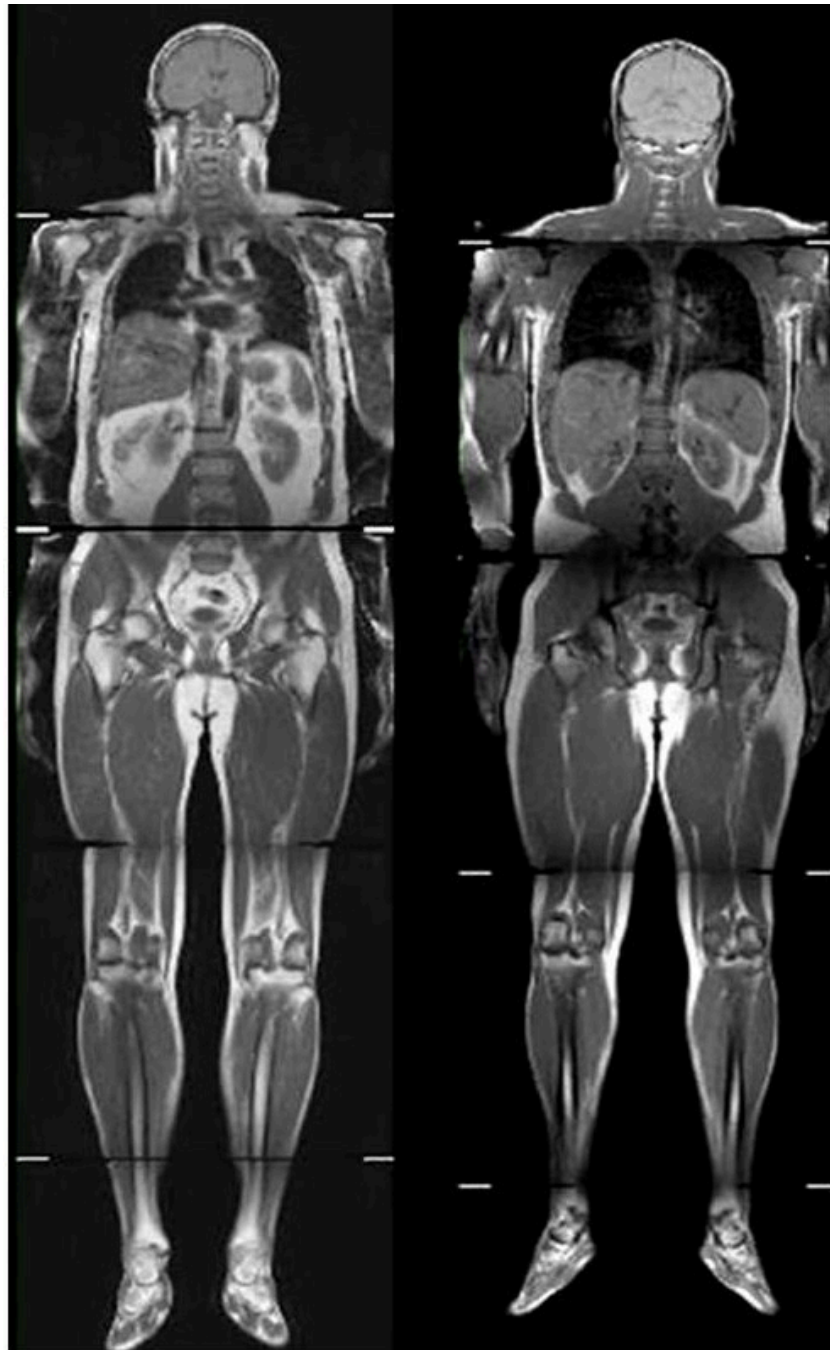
These two x-rays show two males of comparative age, sex and body fat, but different heights. Notice that the lung size is smaller in the shorter person on the right (there is a bit of lung collapse here as well). Photo by ImagingFat, CC BY-SA 3.0
